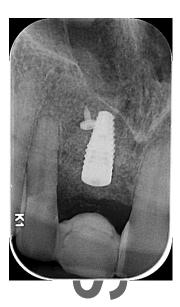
Radiographic outcome of uncovery and healing abutment connection.
